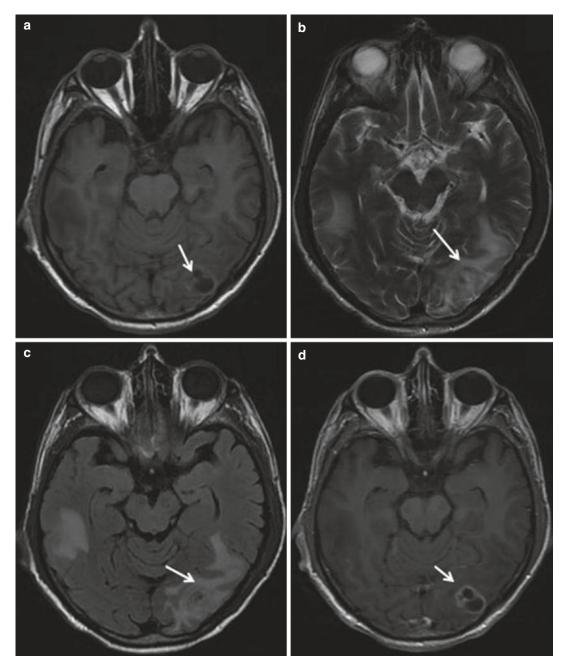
MR imaging findings in case of a tuberculous brain abscess (TBA) with perilesional edema in left parieto-occipital region (*arrows*). T1-W image shows a hypointense lesion with a hyperintense wall (a). Mixed
